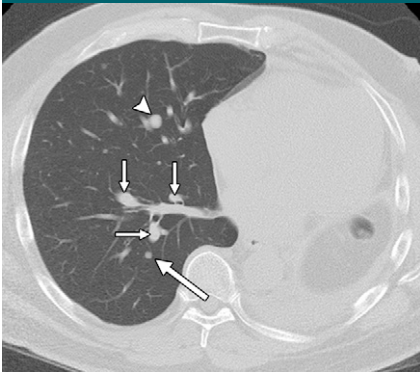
Single axial chest CT image shows it can be difficult to differentiate a lung nodule from a vessel of similar size. The central nodule (arrowhead) in right middle lobe is of the same size as the segmental vessels (small arrows) in right lower lobe. The tiny nodule (large arrow) in the posterobasilar segment of right lower lobe is more readily understood because of the lack of adjacent vessels.
